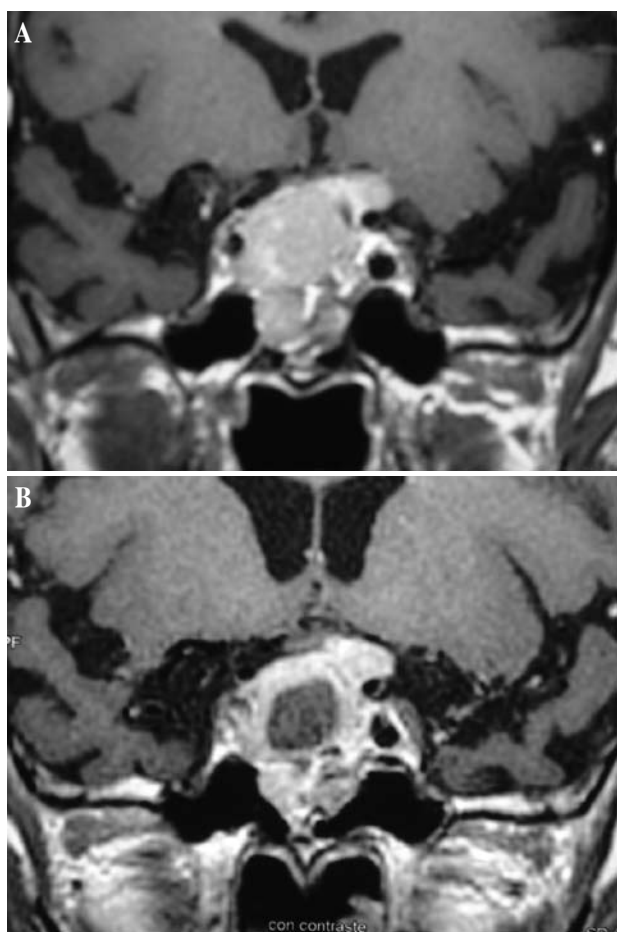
Coronal, T1-weighted MRI with gadolinium enhancement shows a sellar and suprasellar tumor with chiasmal compression (3A). Coronal, T1-weighted MRI with gadolinium enhancement shows a spherical, hypointense, intratumoral area indicating involution of the tumor after five cycles of Temozolomide treatment (3B).
